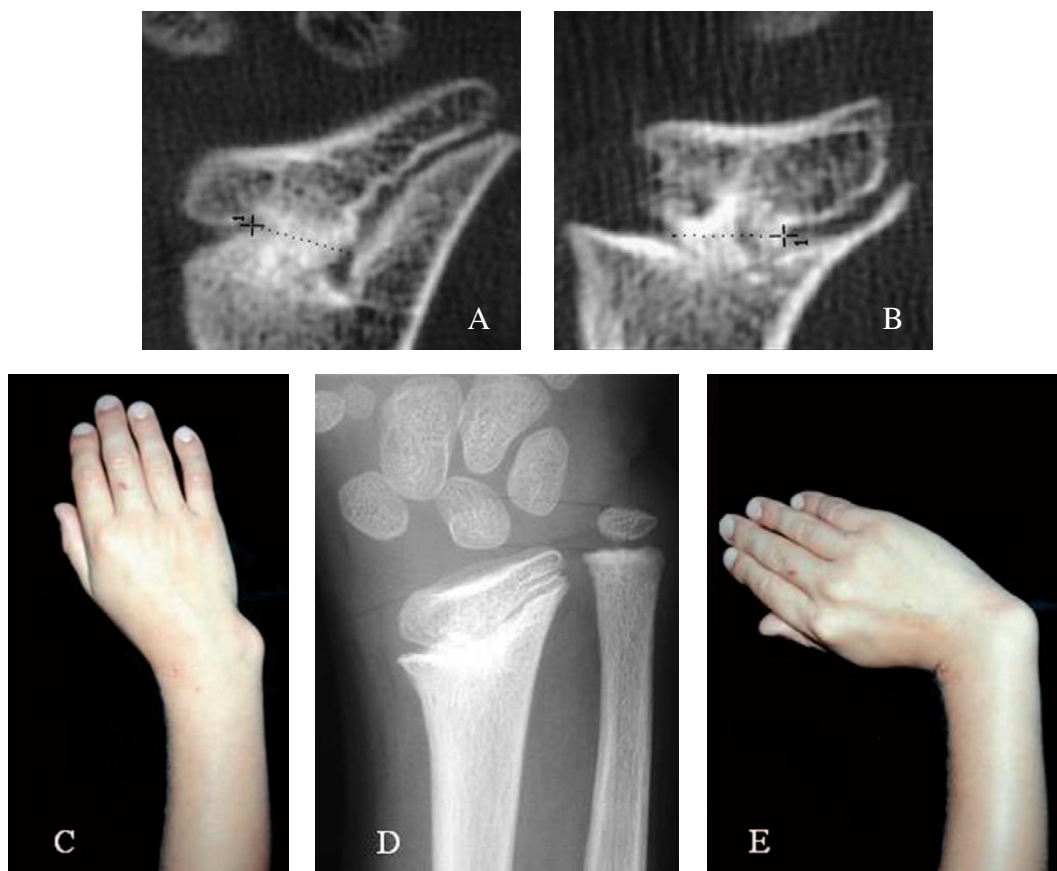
Partial epiphyseal closure at age 9, 2 years after a fracture of the distal radius (C and E: wrist in radial deviation). Radiograph (D) and scans (A and B) reveal marked ulnar overgrowth and radial tilt of the radius.
